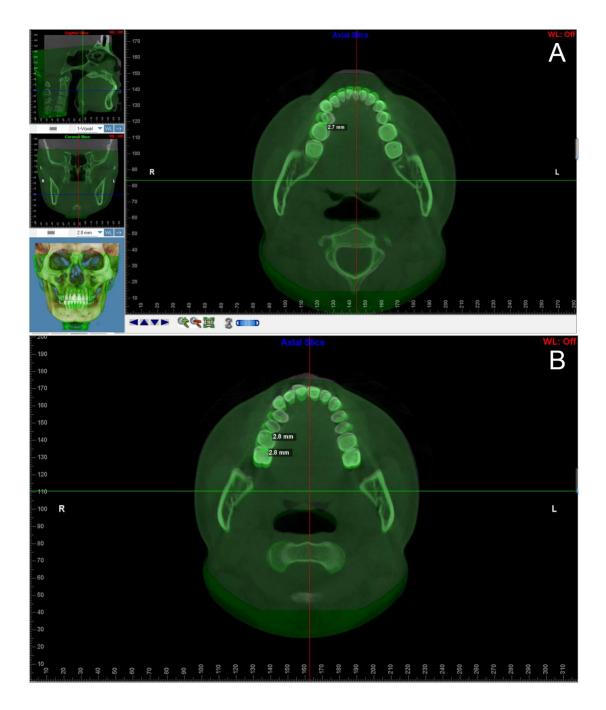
Superimposition of pretreatment and posttreatment CBCT images (*gray*: before treatment; *green*: after treatment). (A) The mandibular right first molar was distalized by 2.7mm. (B) The maxillary right molars were distalized by 2.8mm.
